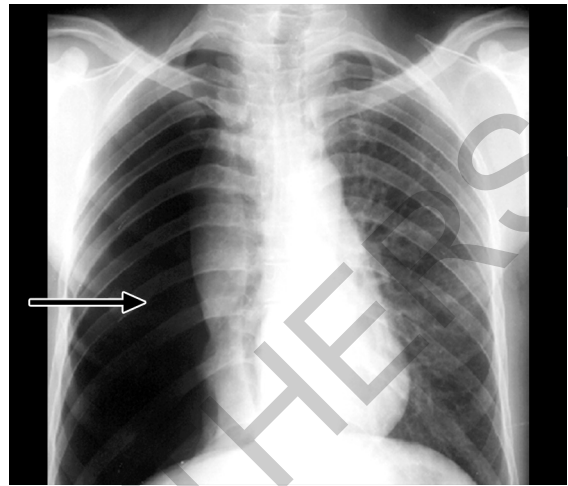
X-ray findings—show a pleural line that runs down the chest wall. The trachea is shifted toward the unaffected side.
